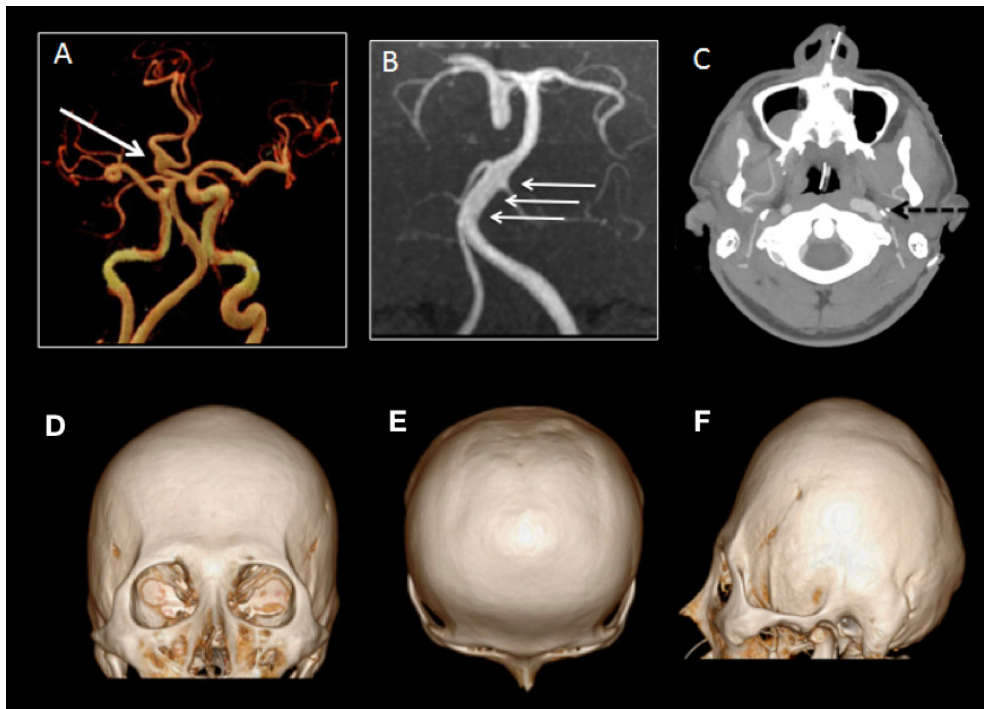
Computed tomography (CT) angiogram of the brain showed an aneurysm of the azygos anterior cerebral artery (ACA) (arrow in A) as well as ectatic and tortuous proximal basilar (arrows in B) and distal left internal cerebral arteries (arrow in C). D to F depict 3-dimensional (3-D) CT images of the cranial vault, demonstrating severe microcephaly and pancraniosynostosis.
